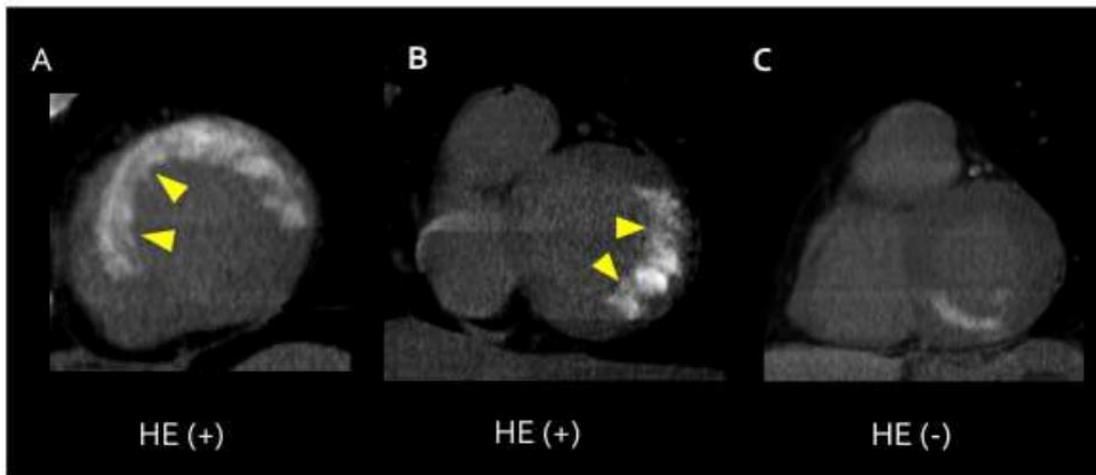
Short-axis DE-CT in 3 patients with acute myocardial infarction. Panels A and B show the presence of HE, and Panel C shows no heterogeneous enhancement. Panel A shows transmural contrast-delayed enhancement in the anterior wall and a hypoenhanced area surrounded by a hyperenhanced layer (arrows), which is a typical finding of microvascular obstruction on DE-MRI. Panel B shows transmural contrast-delayed enhancement in the lateral wall and a patchy enhancement area with hyper- and hypoenhancement segments (arrowheads). Panel C shows subendocardial contrast-delayed enhancement in the inferior wall and no HE. DE-CT indicates delayed-enhancement computed tomography; DE-MRI, delayed-enhancement magnetic resonance imaging; and HE, heterogenous enhancement.
